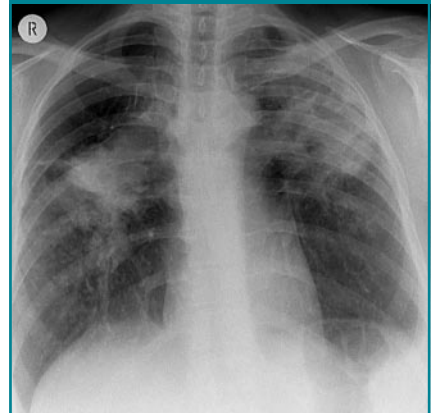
Chest radiograph shows bilateral progressive massive fibrosis.
